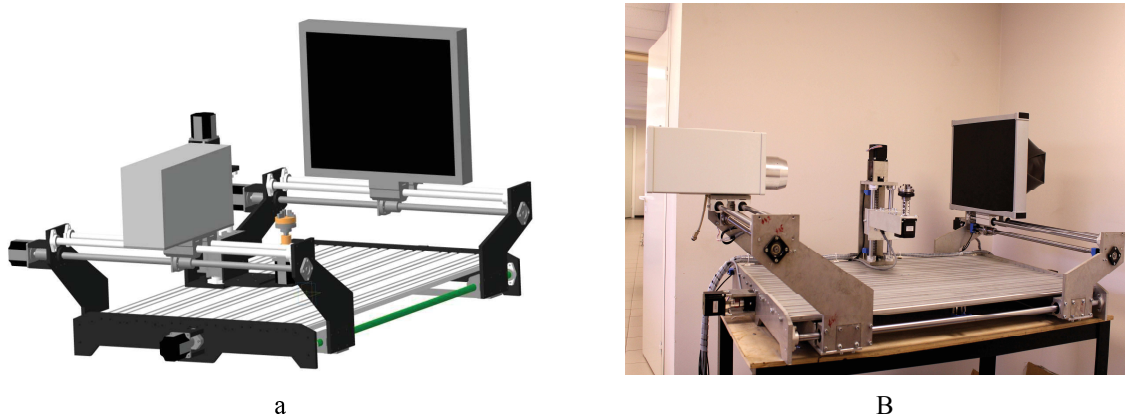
Micro focus X-ray computed tomograph (MFCT-01):
